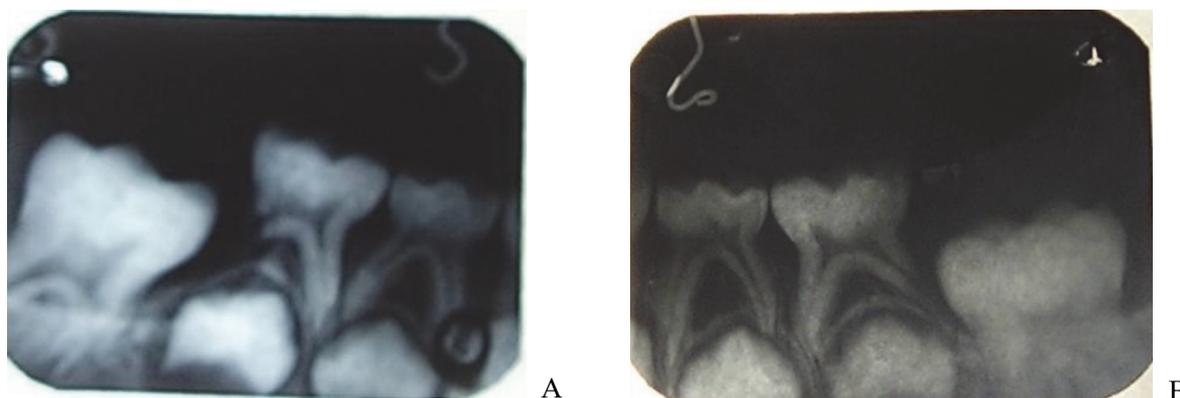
X-ray picture of follicular cysts from 36 (A) and 46 (B) teeth that were associated with eruption cysts.
